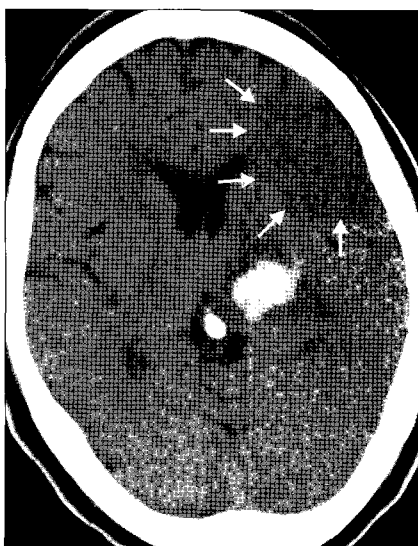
After hospital 4day, follow up brain computed tomography revealing an cerebral infarction at the left middle cerebral artery territory (white arrows).
